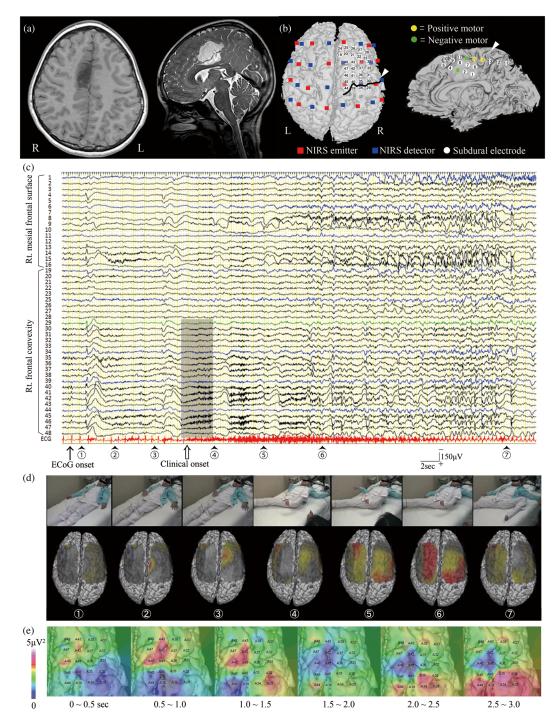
Results of the ictal NIRS-ECoG study. (a) Preoperative magnetic resonance T1-weighted axial and T2-weighted sagittal images, showing a significant lesion extending to the right supplementary motor area. The characteristic appearance of iso T1 and high T2 signal intensity indicates a dysembryoplastic neuroepithelial tumor. (b) Placement of NIRS probes and subdural electrodes, and the results of cortical mapping. The bilateral motor associated frontal surfaces were sufficiently covered by the placed probes. The central sulcus is indicated by the thick black line and white arrowheads. Eighteen electrodes, each assigned numbers from 1 to 18, covered the right mesial surface and 30 electrodes, each assigned numbers from 19 to 48, covered the right frontal convexity. Each electrode number corresponds to those in Fig. 1(c) and 1(e). Positive motor areas (electrodes depicted in yellow) and negative motor areas (electrodes depicted in green) were identified on the right mesial frontal surface. (c) Ictal ECoG, demonstrated with a reference montage (averaged reference from electrodes #17 and #18). Ictal ECoG onset (black arrow) started with low amplitude fast activity predominantly at #46, determined to be a SOZ from interictal ECoG, approximately 8 s before clinical onset (white arrow) and followed by sharp-slow complexes predominantly at the SOZ (#46) and the neighboring premotor cortex (#41 to #43, #47 and #48). As the seizure entered the tonic phase, epileptic discharges showed higher amplitude, spread diffusely, and lasted longer (up to 17 s). A 3-s epoch (shaded in grey) at 20 electrodes (#29 to #48), where the most prominent HFOs were obtained, was placed for making the topographic images of the averaged powers as shown in Fig. 1(e). (d) Consecutive topographic images on ictal NIRS (lower row) and the corresponding seizure appearance (upper row). Each number (10 through 20) corresponds to the numbers in Fig. 1(c), shown above. See text for details. (e) Consecutive 3-s topographic images, showing that high-power HFOs (80 to 220 Hz) start at the SOZ (#46) and PMC (#41 to #43), then shift to the SMC (#29, #30, #34, #35, #39, and #44) 1.5 to 2 s later. Intriguingly, this propagation pattern was very similar to that of the right hemisphere in the NIRS study, starting at the SOZ (2), and the right PMC (3) and then continuing to the right SMC (S) as shown in Fig. 1(d).
